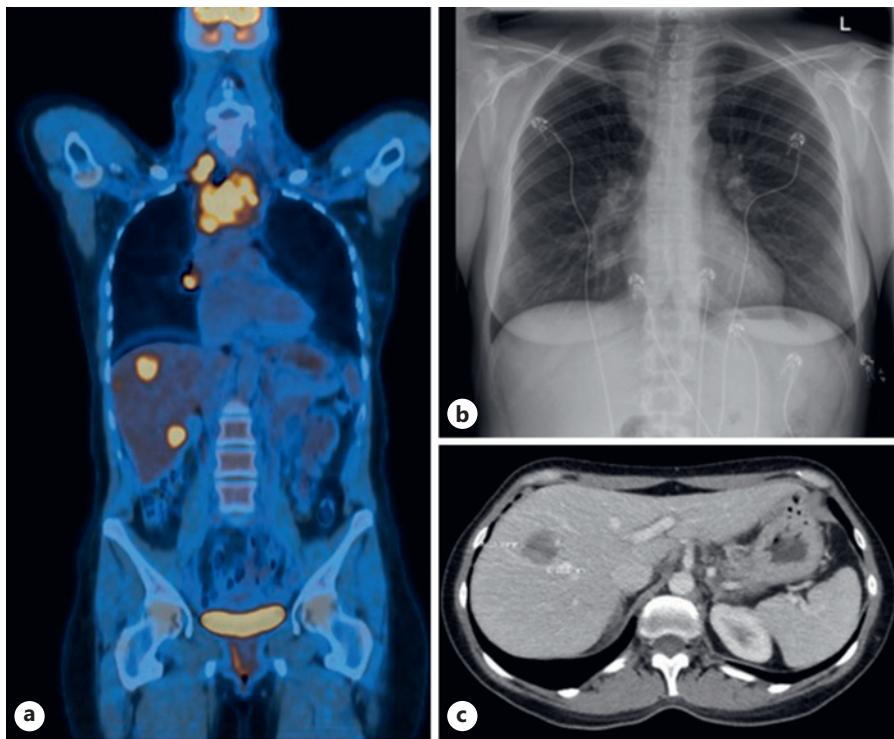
Image series of metastatic thymic carcinoma. a Coronal PET CT showing thymic carcinoma with liver lesions. b Chest X-ray showing thymic mass. c Axial CT upper abdomen showing liver metastases.
